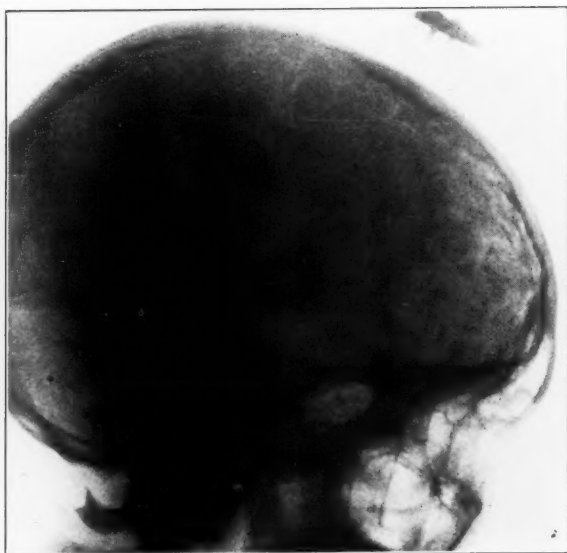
Case 1.—Roentgenogram showing the reformation of the frontal bone and the frontal sinus.
